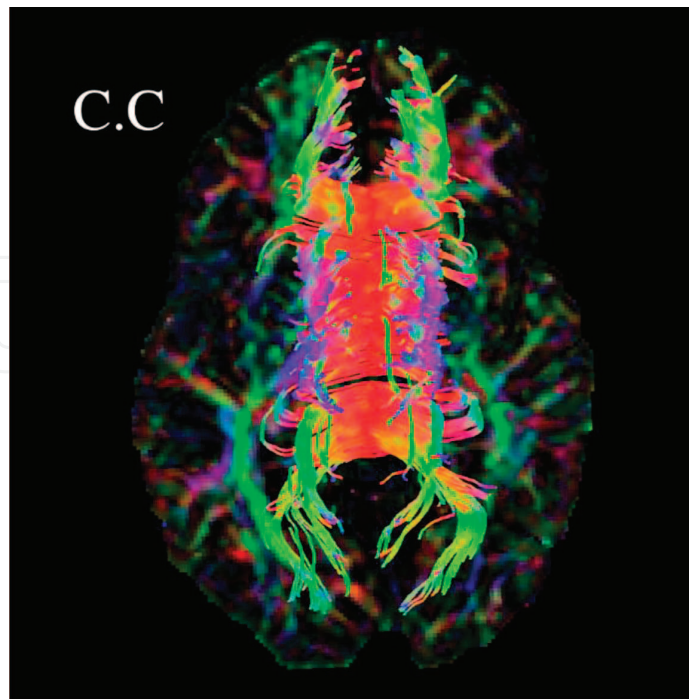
MRI tractography in axial view showing corpus callosum (C.C) fibers.
